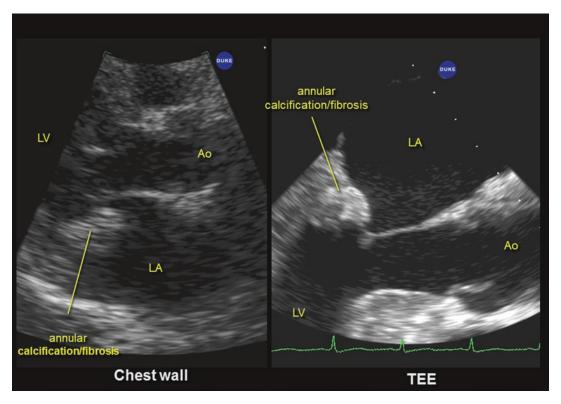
Chest wall and transesophageal echo still frames from a patient with mitral valve fibrosis/calcification. Since there no shadowing, calcification cannot be inferred
